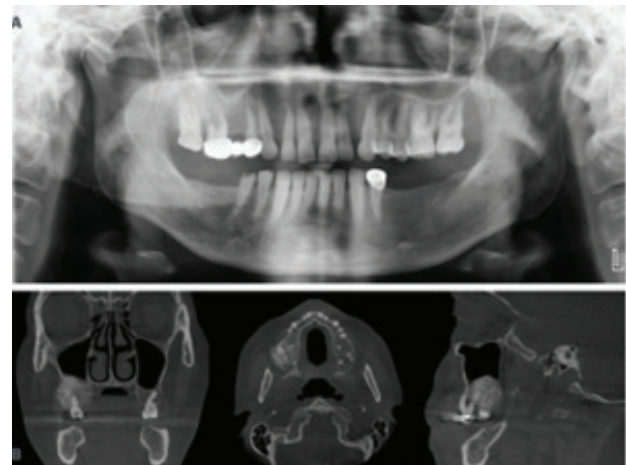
Radiographic images; panoramic radiograph (A) and CBCT sections (B).
